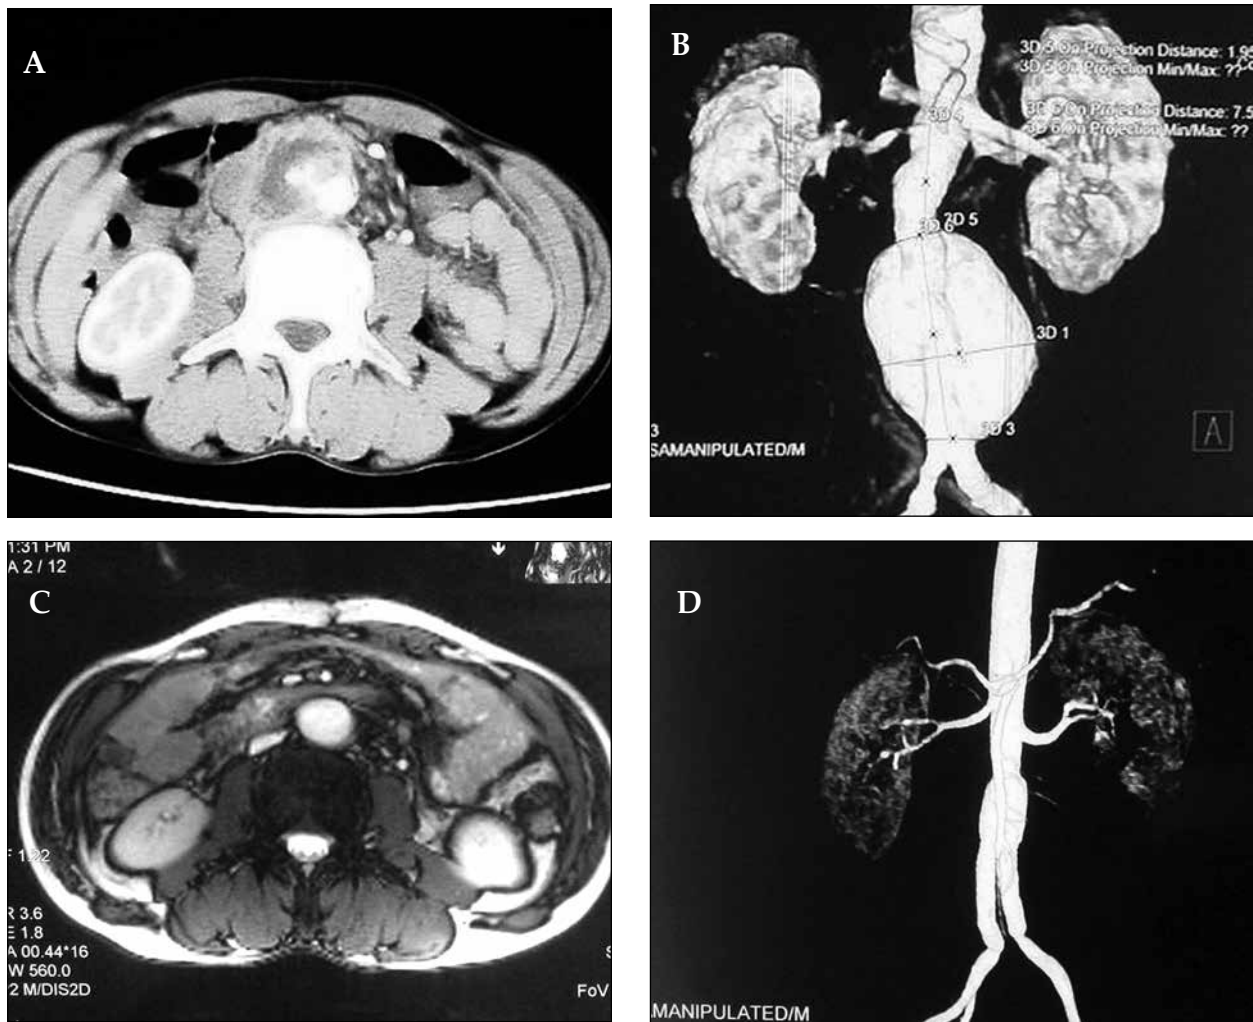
Tuberculous false aneurysm of infrarenal abdominal aorta in a 51-year-old male. (a) Enhanced CT scan demonstrating the dilatation of abdominal aorta and inflammatory thickening of the vessel wall. (b) CT angiography showed a sacular false aneurysm measuring 8 x 6 cm in the infrarenal abdominal aorta without involving bilateral renal artery and bilateral iliac artery. (c) Postoperative CT scan exhibited smooth abdominal aortic wall and complete disappearance of periangiitis. (d) Postoperative CT angiography showed the normal profile of abdominal aorta.
